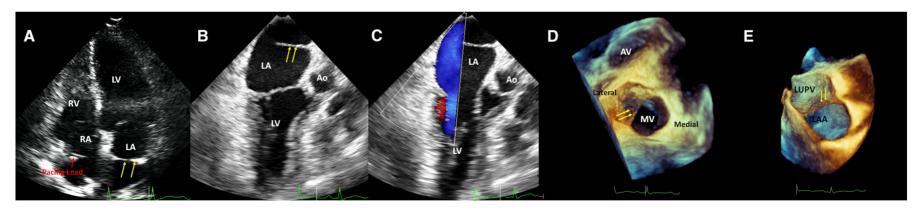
Echocardiographic images of a patient with asymptomatic cor triatriatum.
